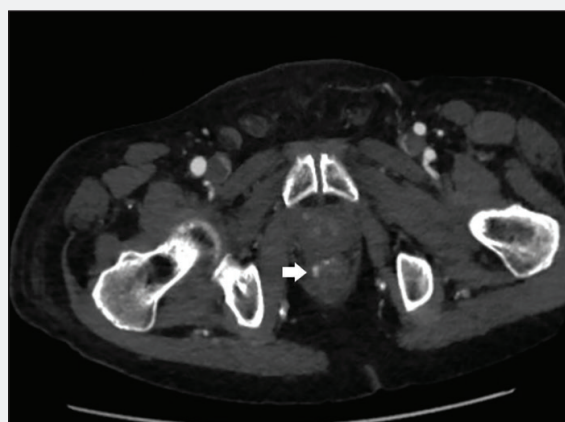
CTA of the abdomen and pelvis showing bleeding of the internal hemorrhoids.
